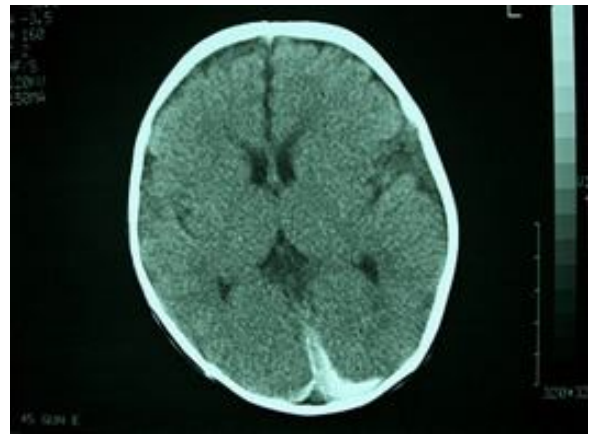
Cranial CT scan of a patient with subdural hemorrhage and frontal subdural effusion.
